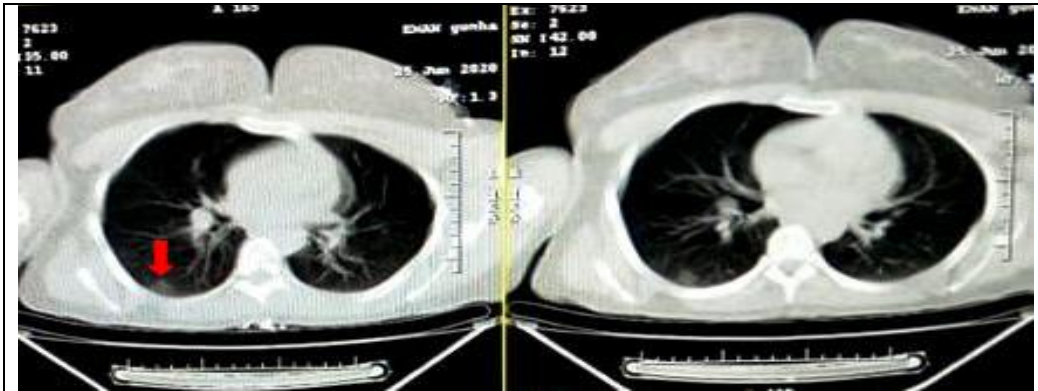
25 year's old female has no notable signs but was in direct contact with infected patient with virus (COVID-19), images (A&B) axial chest CT image showed small patchy ground-glass opacities (arrow) located along vascular bundles in the subpleural region.
